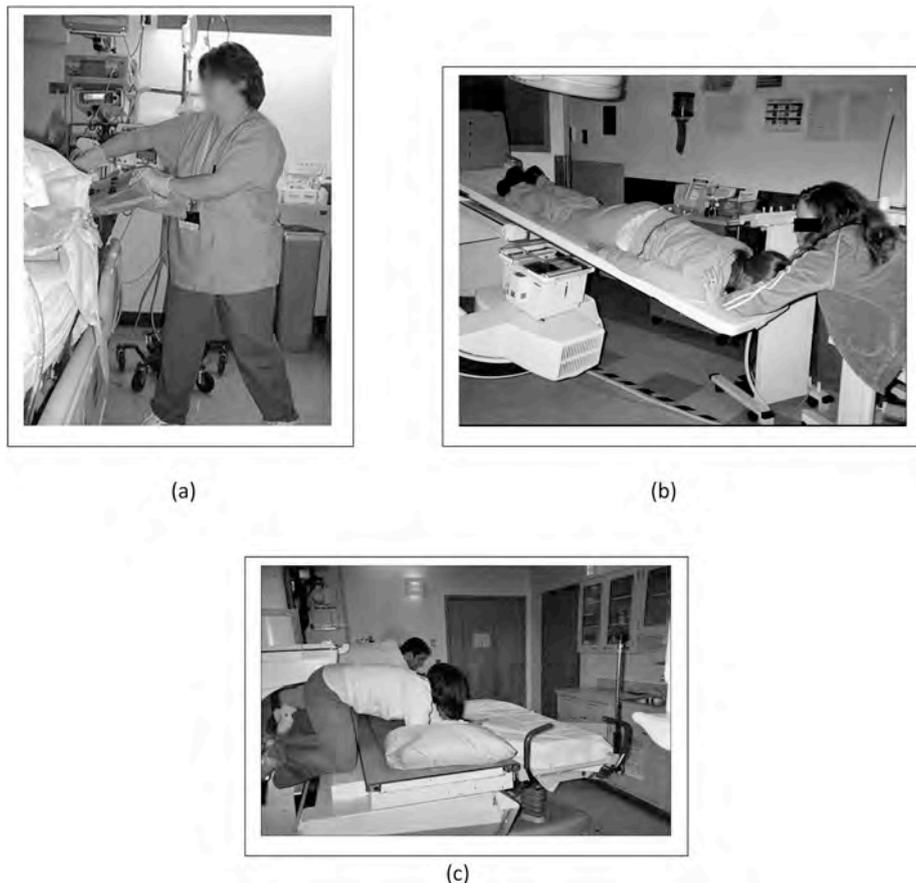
Common, physically stressful tasks performed by radiologic technologists. (a) Positioning a receptor under a patient during a portable exam; (b) supporting a patient to keep patient from sliding off the fluoroscopy table (demonstration); (c) lateral transfer of patient from gurney to x-ray table (demonstration of position, patient would be on gurney).
